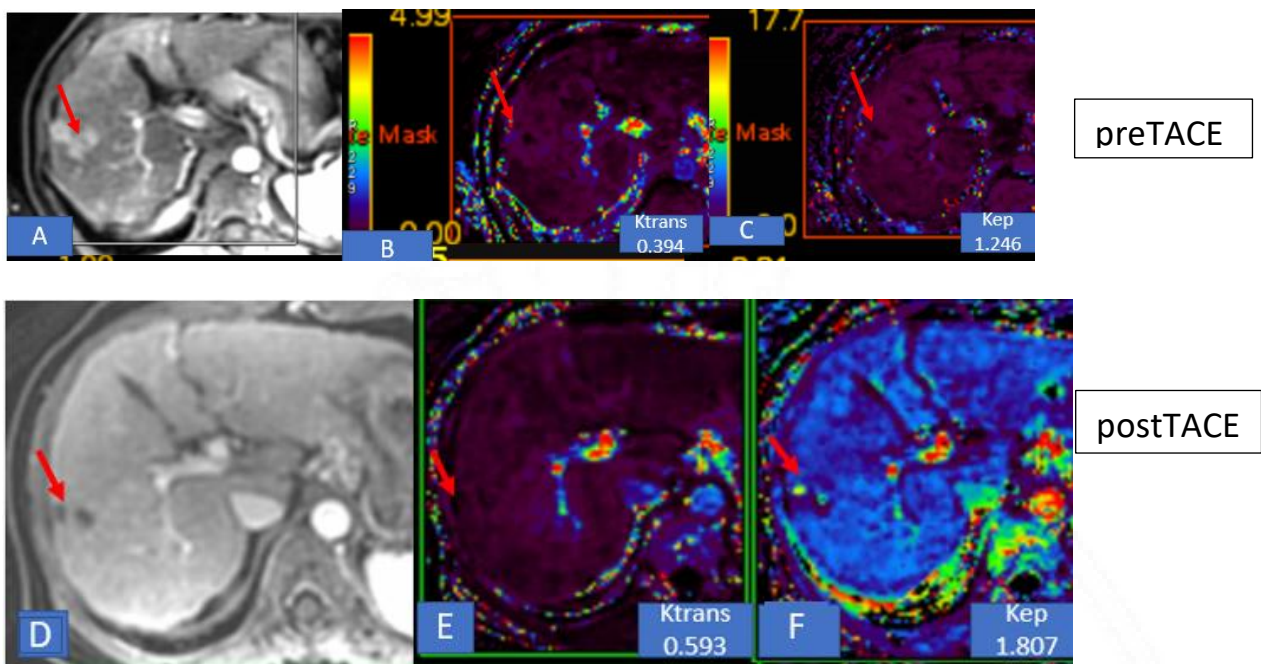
A HCV patient with complete response HCC lesion. DCE MRI showing lesion with contrast enhancement in preTACE MRI(A), which showed no enhancement and significant decrease in size with a complete response in postTACE DCE MRI. Paradoxical increase in Ktrans(B&E) and Kep values (C&F) after TACE which may be due to reduction in the size making it difficult to place ROI corresponding to the preTACE image(arrows).
